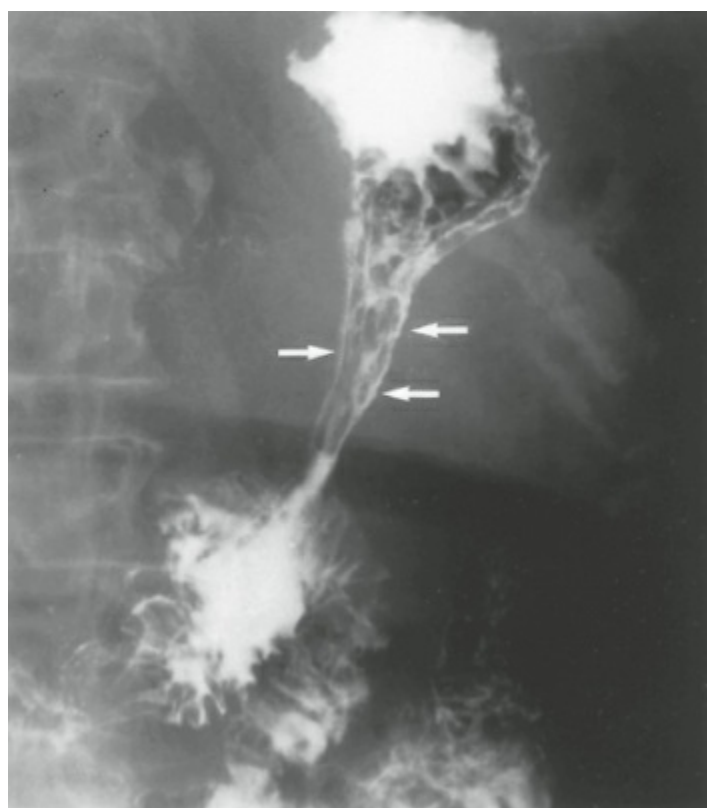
Barium-contrast radiograph demonstrating extensive involvement of the gastric body by infiltrating adenocarcinoma (linitis plastica). The gastric silhouette is narrowed (*arrows*), and the stomach is nondistensible.
